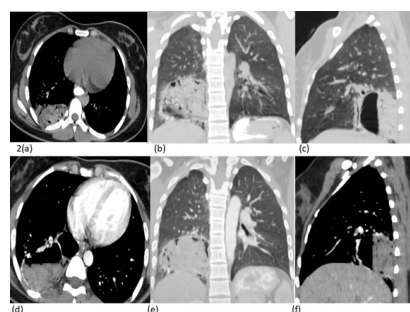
CT of chest plain with oral and IV contrast AXIAL (a,d), CORONAL (b,e), SAGITTAL (c,f) showing intralobar pulmonary sequestration in right medial posterior basal segment.
